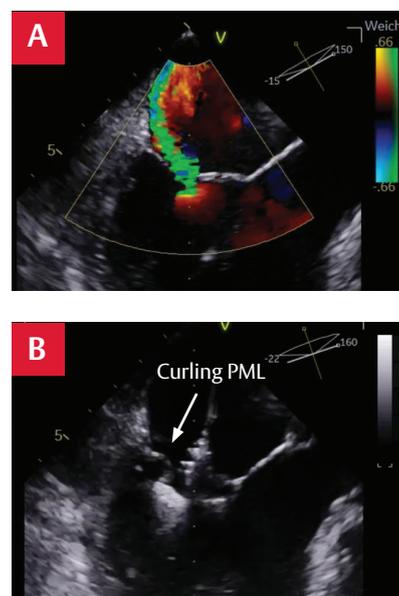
2D echocardiography of the mitral valve at baseline.
